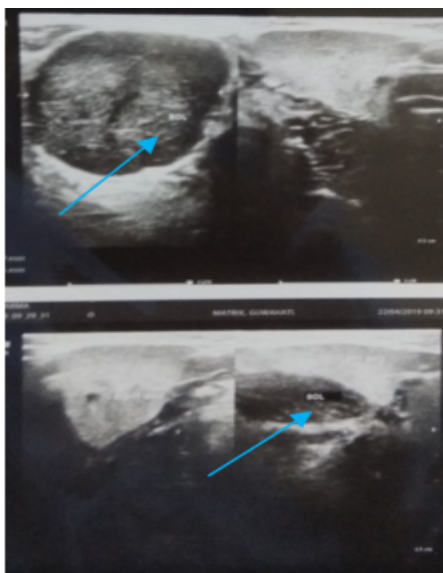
High resolution ultrasonography showing hypoechoic and exophytic space occupying lesion (blue arrow) in left submandibular gland.
